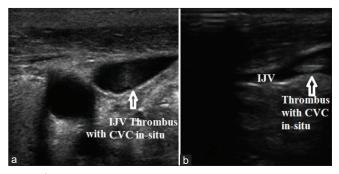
Ultrasound image showing the presence of thrombus in the right IJV with CVC *in situ*. (a) Short-axis view and (b) long-axis view of IJV. IJV: Internal jugular vein, CVC: Central venous catheter
